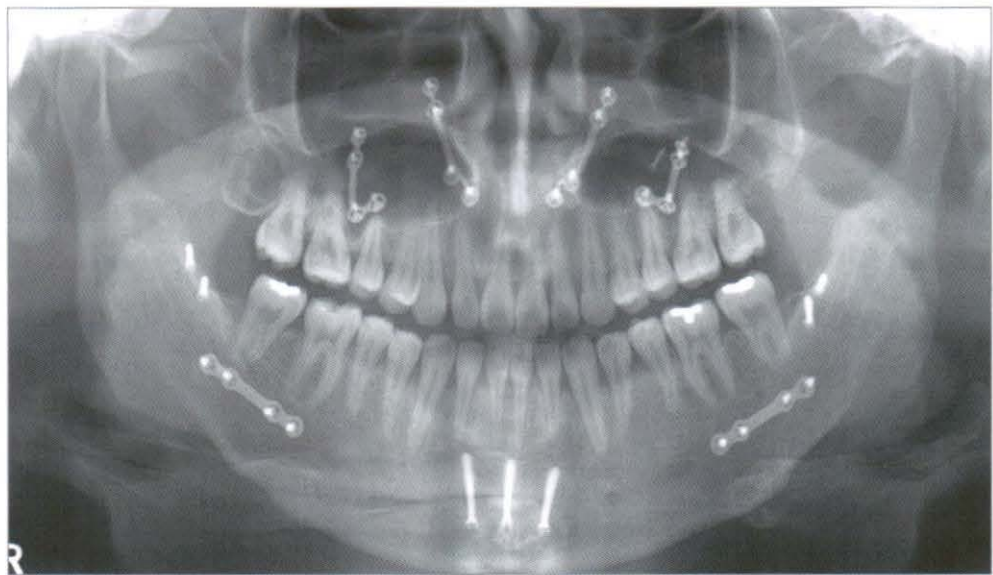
Panoramic radiograph at debonding
